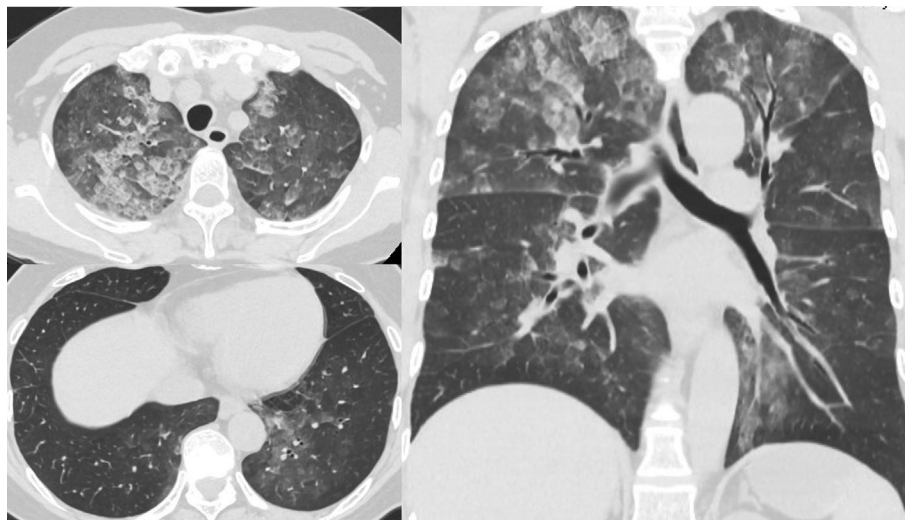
Chest computed tomography images on admission. (A) Diffuse centrilobular ground-glass opacities and septal lines in the bilateral upper lung lobes in axial view. (B) Faint ground-glass opacities in the left lower lobe in axial view. (C) Similar findings in coronal view
